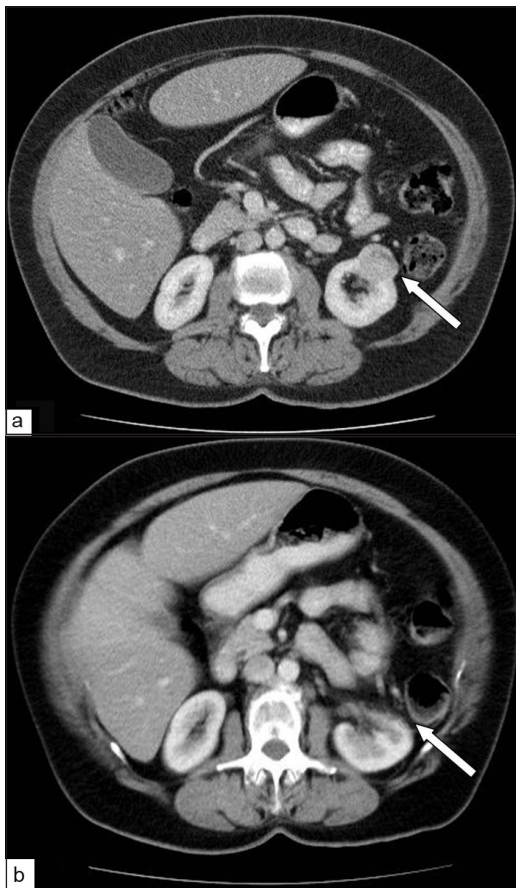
A small left renal mass is seen on a pre-LCA CT scan (a, white arrow). The post LCA CT scan of the same patient shows complete dissolution of the tumor at seven months following cryoablation (b).
